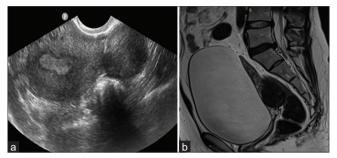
Transvaginal USG depicting a well defined hypoechoic lesion in subserosal location arising from posterior myometrium contour. (a) T2-weighted sagittal (b) showing a hypointense subserosal fibroid arising from posterior myometrium
